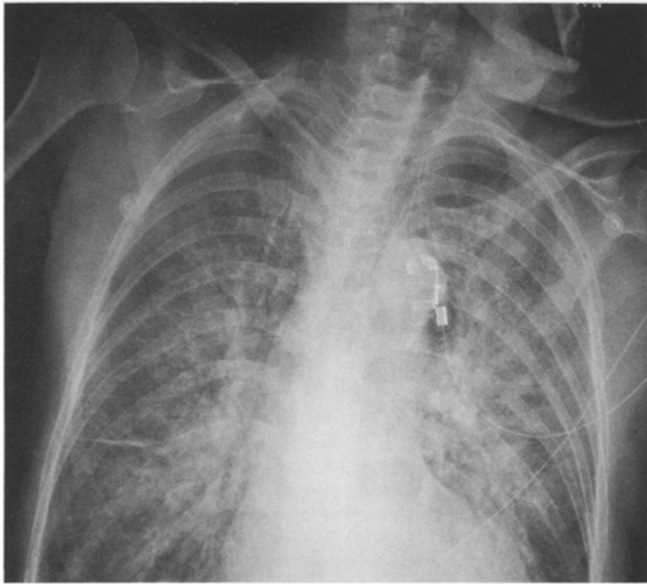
Chest X-ray on the day of admission showing diffuse bilateral pulmonary edema
